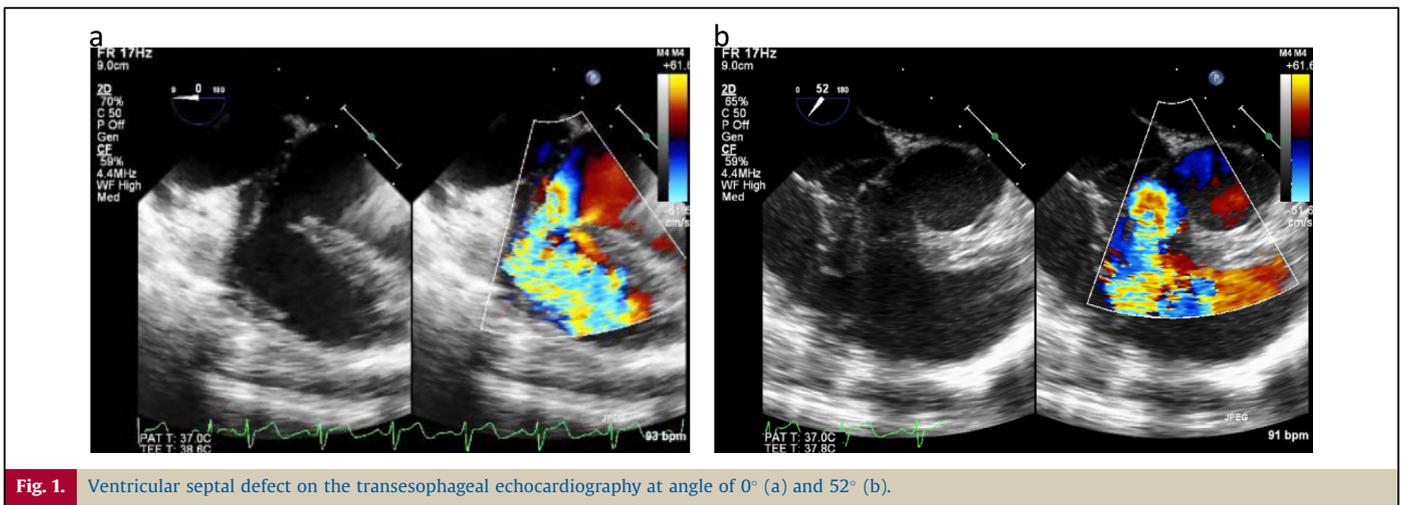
Ventricular septal defect on the transesophageal echocardiography at angle of 0° (a) and 52° (b).
